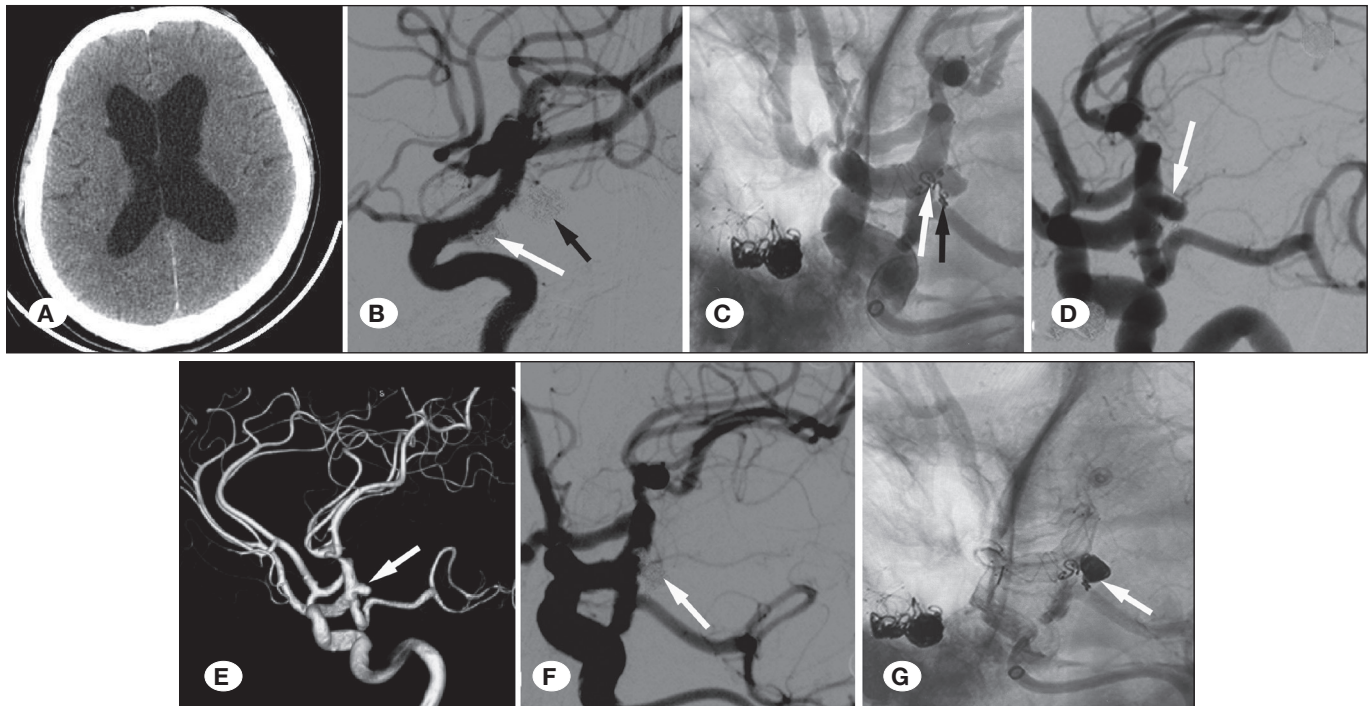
Images of the fourth procedure (January 2021). A) Brain CT revealed no sign of subarachnoid hemorrhage, but mild hydrocephalus. B) DSA revealed that the first (white arrow) and third (black arrow) treated aneurysms, respectively, at the posterior communicating and choroidal segments of the right ICA, were stable. C) DSA demonstrated that the coils of the second treated aneurysm at the choroidal segment of the left ICA were shifted from the previous position (shifting from the black arrow to the white arrow). D, E) DSA and 3D-DSA revealed a newly developed aneurysm at the posterior communicating segment of the left ICA. F, G) Postoperative DSA revealed complete occlusion of the aneurysms at the posterior communicating and choroidal segments of the left ICA.
